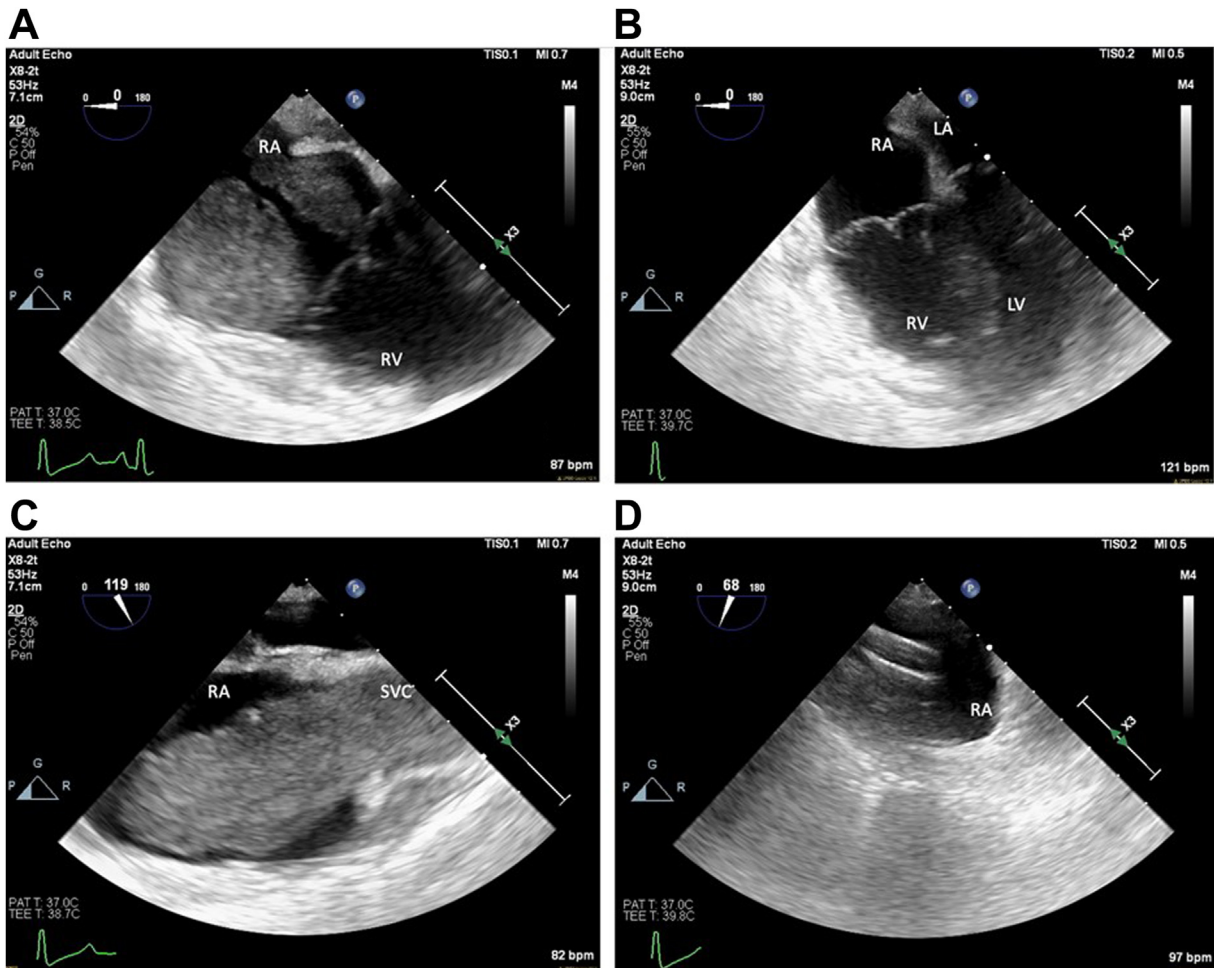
Case 1. A, C: A 7.4 cm \times 1.8 cm mass visualized from superior vena cava extending to tricuspid valve in 4-chamber and bicaval transesophageal echocardiography (TEE) views, respectively. B: Postaspiration images in 4-chamber TEE view. D: Triever catheter visualized in right atrium post aspiration. LA = left atrium; LV = left ventricle; RA = right atrium; RV = right ventricle; SVC = superior vena cava.
